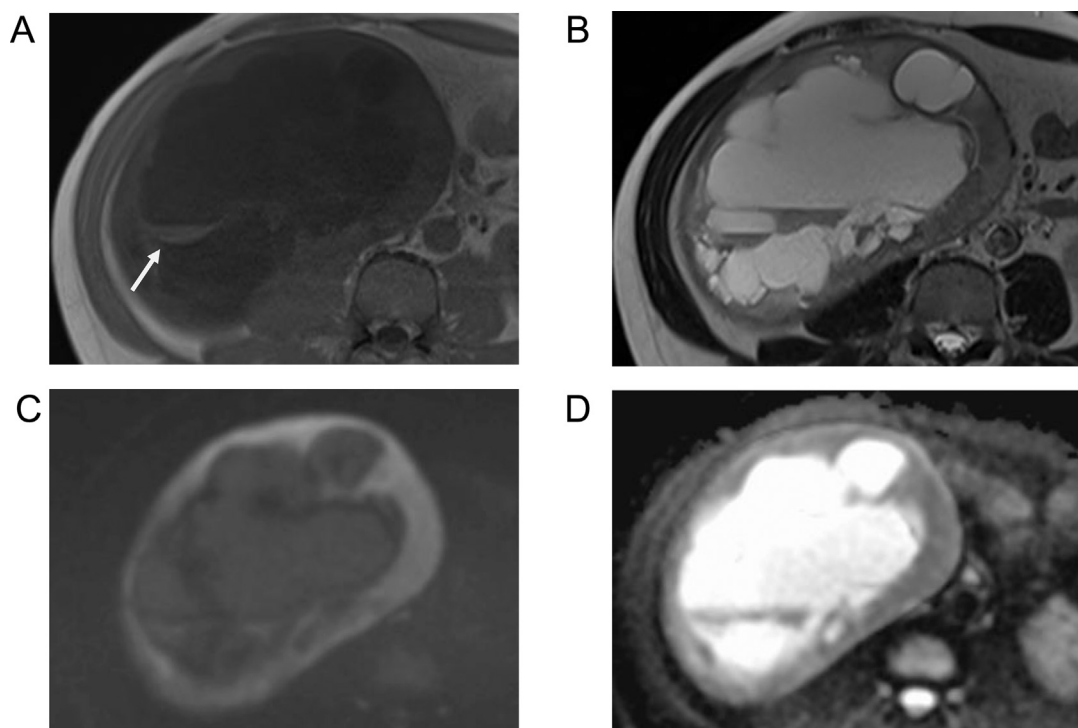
MRI (3.0T). (A) T1WI, (B) T2WI, (C) DWI, (D) ADCmap. Most cysts within the tumor appear as low signal on the T1WI and T2WI. Some cysts are found to possess internal fluid levels, which appear as a high signal on T1WI (arrow), suggesting the presence of a hematoma. The solid part of the tumor displays a uniform signal that appears as high on the DWI, whereas its ADC value ranges from 1.1×10^{-3} to $1.3 \times 10^{-3} \text{mm}^2/\text{sec}$.
